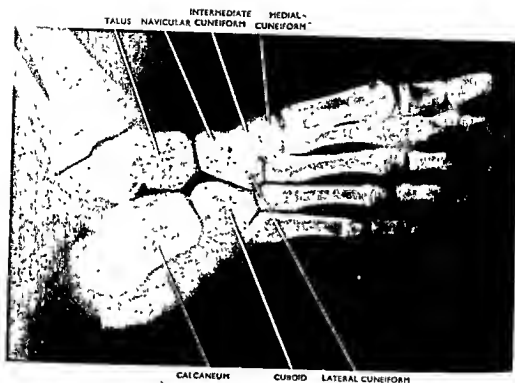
The oblique dorsal radiograph of the foot of a boy of nine years.
